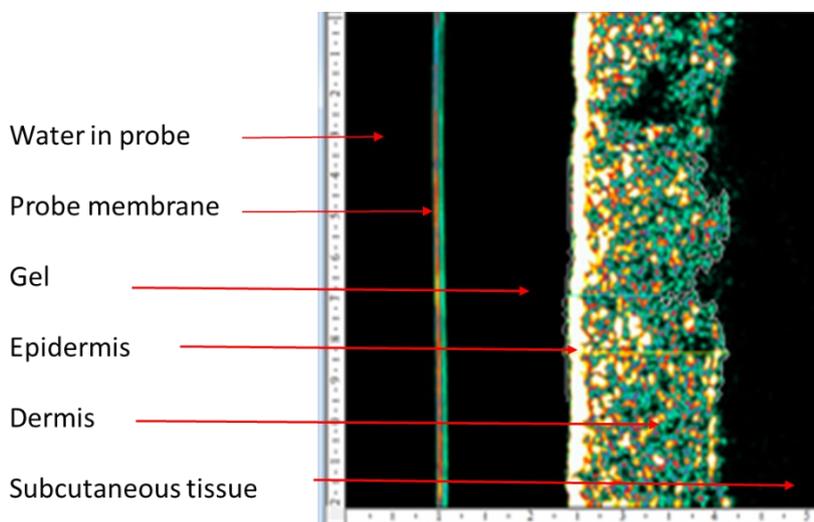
Image of Dermis in Healthy Skin Using the DermaScan C High Frequency Ultrasound
